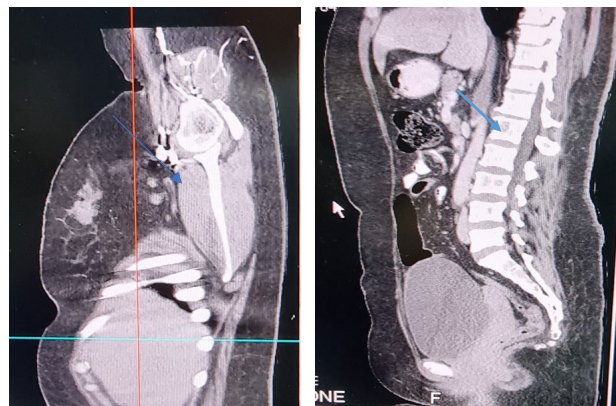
CT scan; sagittal views; reported multiple enlarged lymph nodes noted in the right axillary region. There are hypodense areas noted in the thoracic vertebrae with involvement of the posterior elements. The right scapular blade and spine also have multiple hypodense areas
